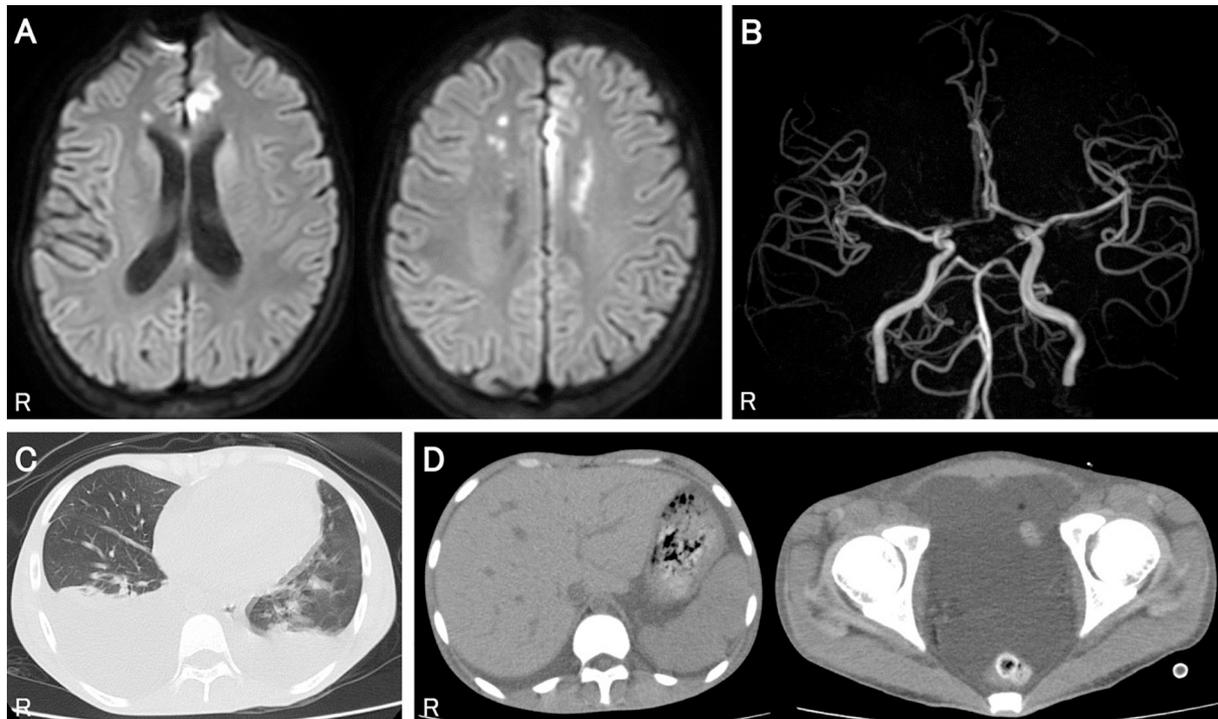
Radiological findings on admission. (A) Brain magnetic resonance imaging showing high-signal-intensity areas in the bilateral anterior cerebral artery region on diffusion-weighted images. (B) Brain magnetic resonance angiography showing no abnormal findings. (C) Chest computed tomography (CT) showing bilateral pleural effusion. (D) Abdominal CT showing ascites and mild splenomegaly.
